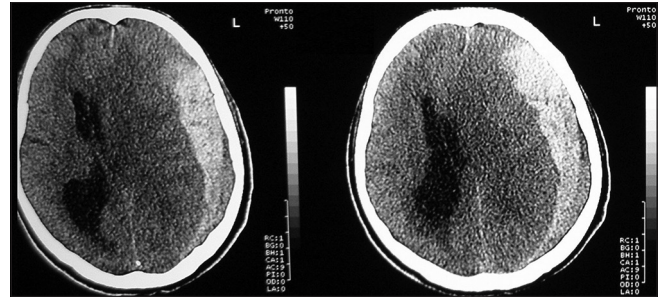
Cranial computed tomography obtained 43 days after initial trauma demonstrated typical acute subdural hematoma on the left with approximately 2-cm shift of the midline structures to the right
